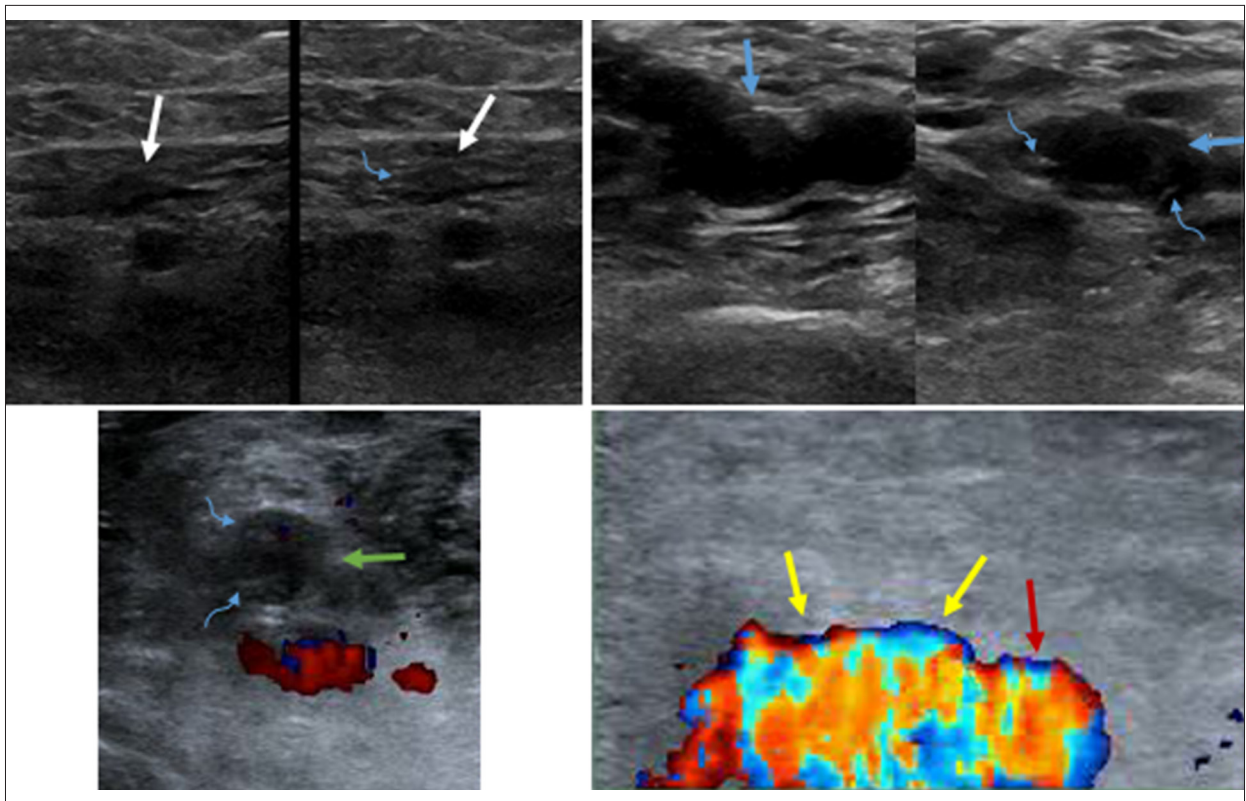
Sonography of the left lower extremity demonstrated echogenic intraluminal structures (curved blue arrows) compatible with deep venous thrombosis (DVT), non-compressible left common femoral (blue arrows), and superficial femoral (white arrows) and popliteal veins (green arrow) in a patient presenting with left leg swelling and discoloration. Note the left common femoral venous patency (yellow arrow) after thrombolysis, thrombectomy, and stenting of left common iliac vein. Patent left common femoral artery (red arrow).
